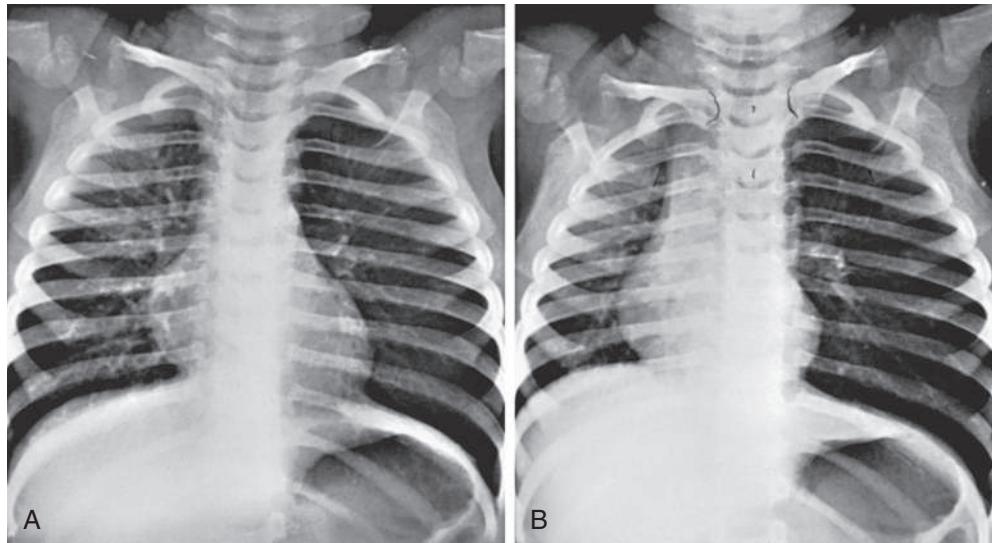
A, Normal inspiratory chest radiograph in a toddler with a peanut fragment in the left main bronchus. B, Expiratory radiograph of the same child showing the classic obstructive emphysema (air trapping) on the involved (left) side. Air leaves the normal right side, allowing the lung to deflate. The medium shifts toward the unobstructed side.
